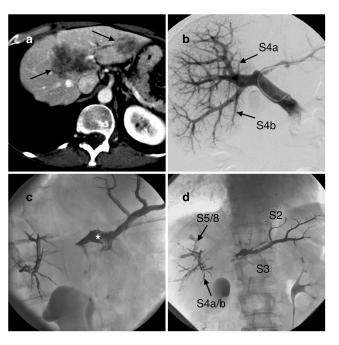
Portal vein embolisation tailored to prepare left hepatectomy extended to right anterior sector in a 62-year-old woman with hepatic metastases of colorectal origin. a Contrastenhanced CT shows two large masses (black arrows) in the left hepatic lobe and segments IV and VIII. b Portography was obtained by an ipsilateral approach in the left portal vein. Two portal branches for segment IV (S4a, S4b) are coming from the right portal vein. c After microcatheter retraction in the left portal vein (white asterisk), EVOH solidifies proximally and, after 3 min, flows backwards in the left hepatic lobe. d Fluoroscopic image at the end of the procedure showing NBCA glue in the portal branches of the right anterior sector (S5/8) and complete occlusion of portal branches in segment IV (S4a/b) and in left hepatic lobe (S2, S3)
